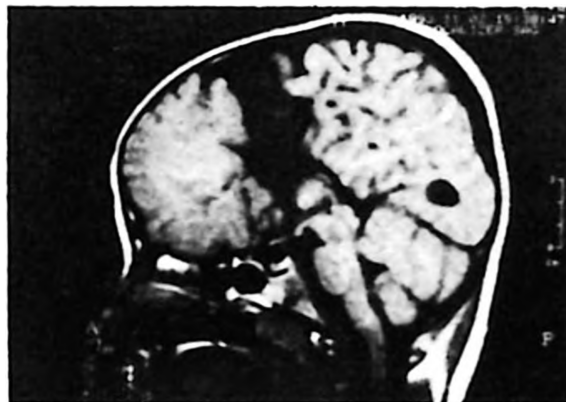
T1-weighted sagittal image shows agenesis of CC and schizencephalic cleft. The presence of gray matter at the lip of the cleft differentiates the schizencephalic cleft from the interhemispheric cyst.
